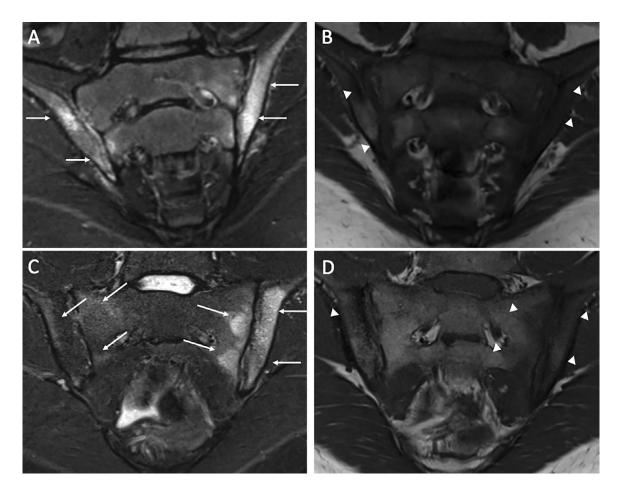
Coronal oblique STIR (A and C) and coronal oblique T1-weighted (B and D) images of the sacroiliac joints of a 7-year-old, HLA–B27– positive female patient (A and B) and a 20-year-old HLA–B27–positive male patient (C and D). There is active sacroiliitis with periarticular bone marrow edema within the iliac aspect of both joints as demonstrated by increased signal intensity on STIR imaging (A; arrows) and decreased signal intensity on T1-weighted imaging (B; arrowhead). There is active sacroiliitis with periarticular bone marrow edema within the sacral and iliac bones, much more intensely on the left than the right, as demonstrated by increased signal intensity on STIR imaging (C; arrows) and decreased signal intensity on T1-weighted imaging (D; arrowheads).
